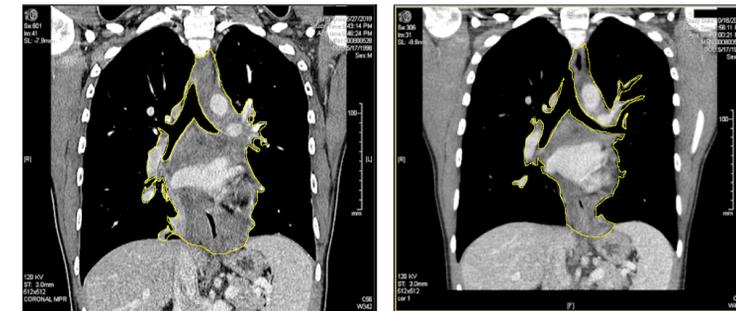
Initial MRI of mediastinal mass prior to treatment (6/27/2019)
